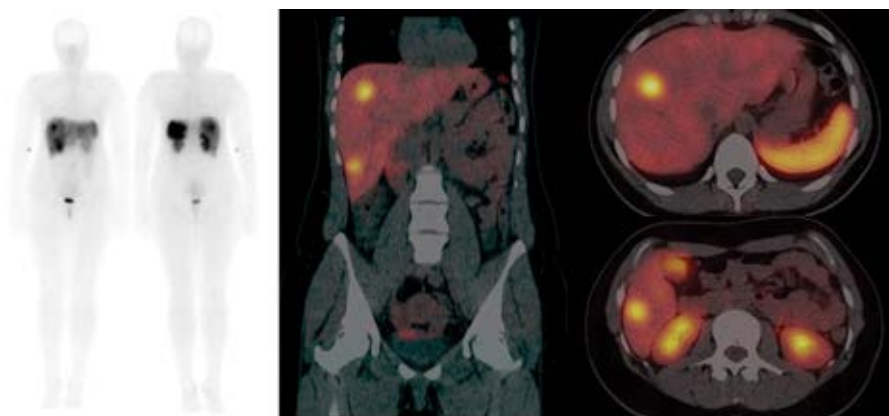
$^{99\text{m}}\text{Tc}$ -HYNICTOC whole-body scan and SPECT/CT showing liver metastasis and paraaortic lymph node. Physiological distribution of radiopharmaceutical in rest of the liver, spleen, and urinary bladder. Injection of radiotracer in the right forearm
